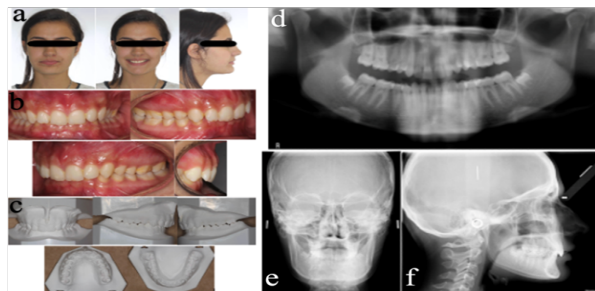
Pretreatment records include (a) extraoral, and (b) intraoral photographs; (c) orthodontic models; (d) panoramic, (e) postero-anterior, and (f) lateral cephalometric radiographs.
